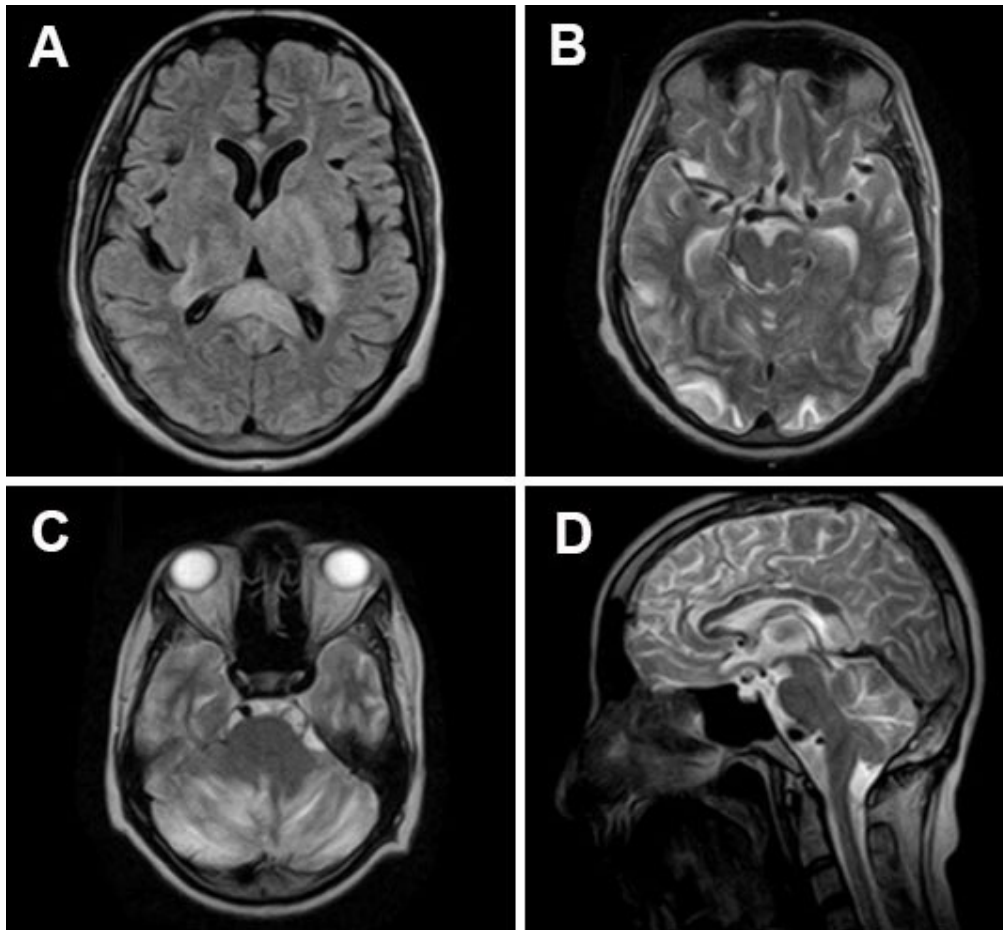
Magnetic resonance imaging in a patient with reversible posterior leukoencephalopathy. FLAIR axial (TR, 6160 ms; TE, 30 ms; TI, 1100 ms; FOV 23 cm × 23 cm; matrix 256 × 192; slice thickness, 5 mm with 1 mm gap) (A); TSE T2-weighted (TR, 4500 ms; TE, 118 ms; FOV 23 cm × 23 cm; matrix 256 × 192; slice thickness, 5 mm with 1 mm gap) axial (B and C) and sagittal images (D) are shown. Figure shows hyperintensities over both thalami, posterior limb of left internal capsule and corpus callosum on FLAIR axial image (A); hyperintense signals are seen over bilateral parieto-occipital cortices (B) and both cerebellar hemispheres (C) on T2 axial images; hyperintensities over corpus callosum and cerebellum are also seen in a T2 sagittal image (D).^[16]
